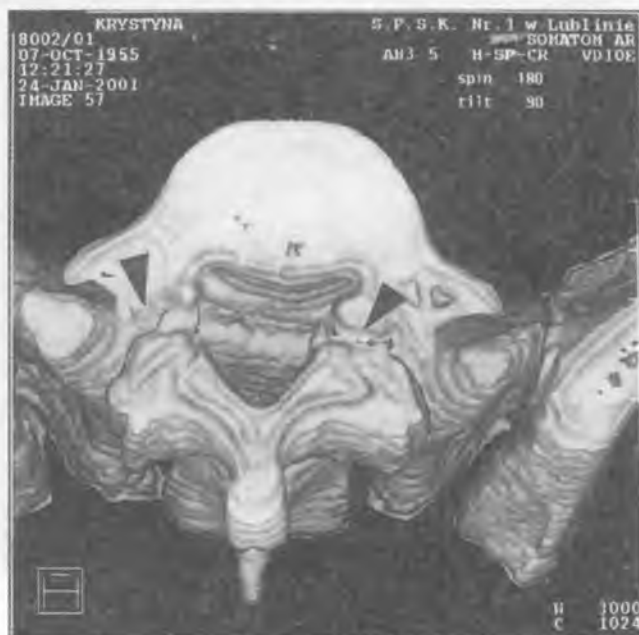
3D CT shows a bilateral arch fissure (arrows). In the lumen of vertebral canal visible posterior edge of S1 body
